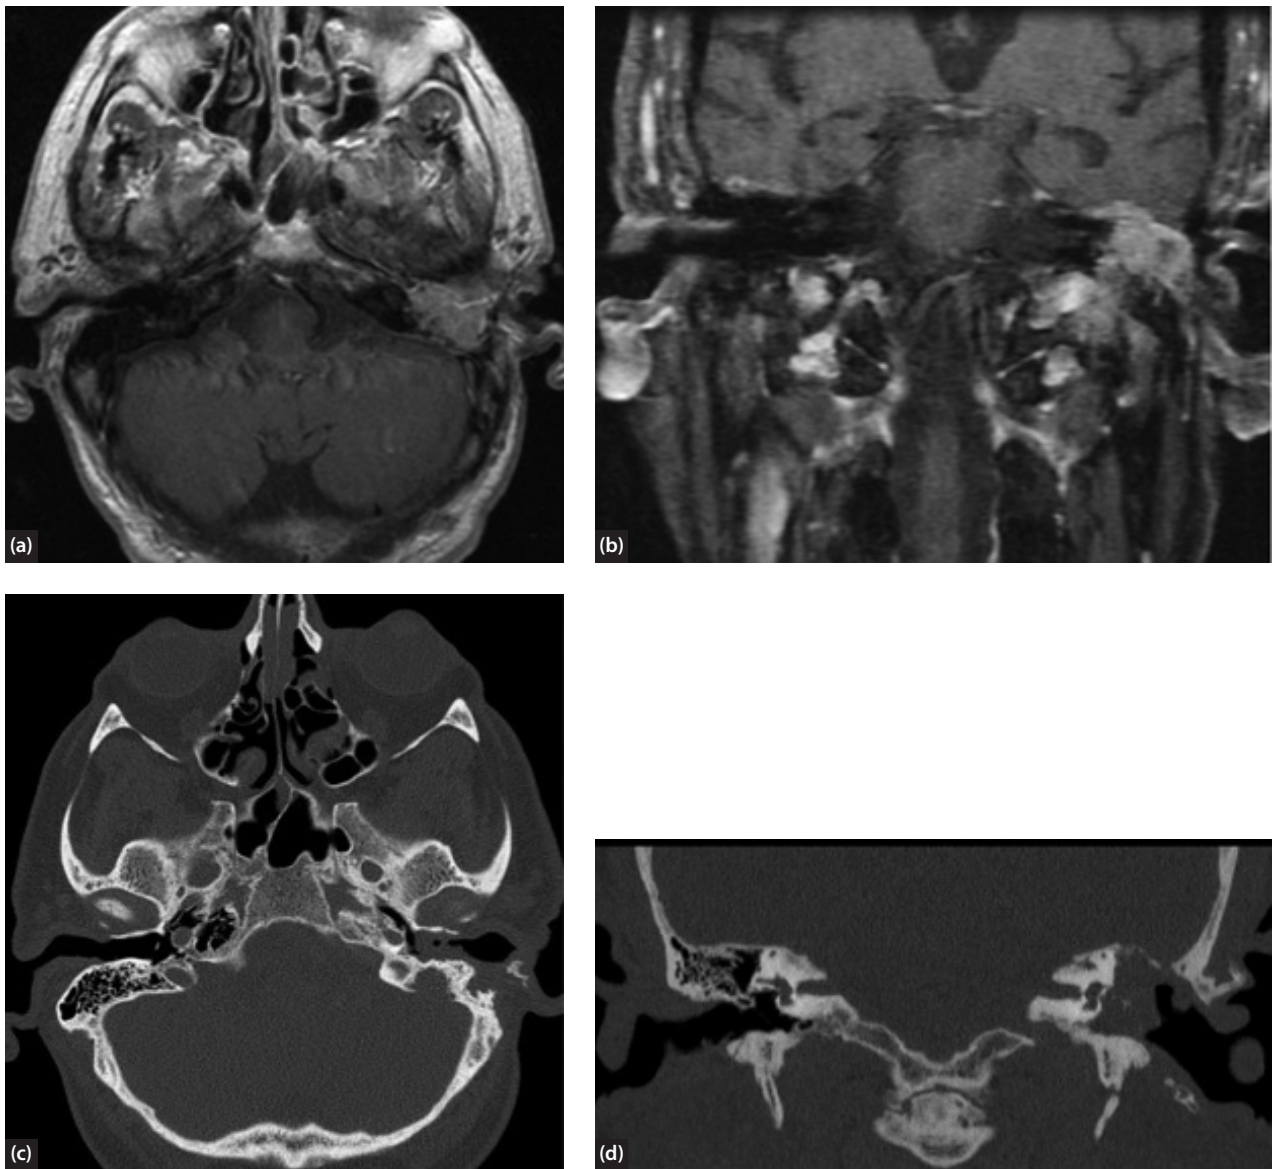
MR imaging with gadolinium enhancement (a) MR axial and (b) MR coronal, showing late stage SCC in the left mastoid cavity with possible invasion of the temporal lobe. CT imaging reveals that the same disease has eroded through the tegmen tympani and mastoid cavity (c) CT axial and (d) CT coronal. Images courtesy of Norfolk and Norwich University Hospitals NHS Foundation Trust.
